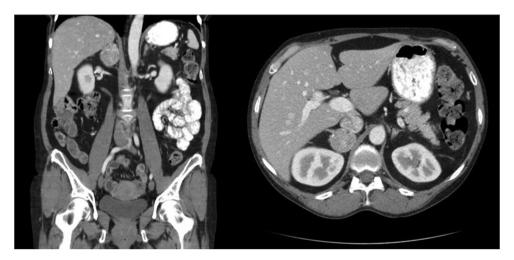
Preoperative abdominal computed tomography scan showing a 3.4 imes 3.0-cm heterogeneously enhancing right adrenal mass.
